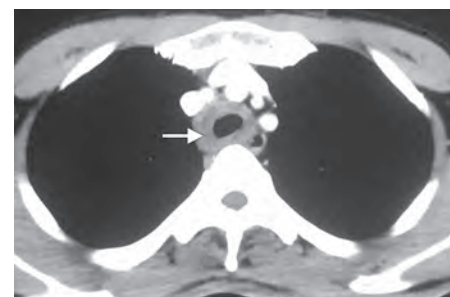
Contrast-enhanced computed tomography (CECT) chest axial section at 4 months follow-up showing circumferential thickening of the trachea with luminal compromise (white arrow)
